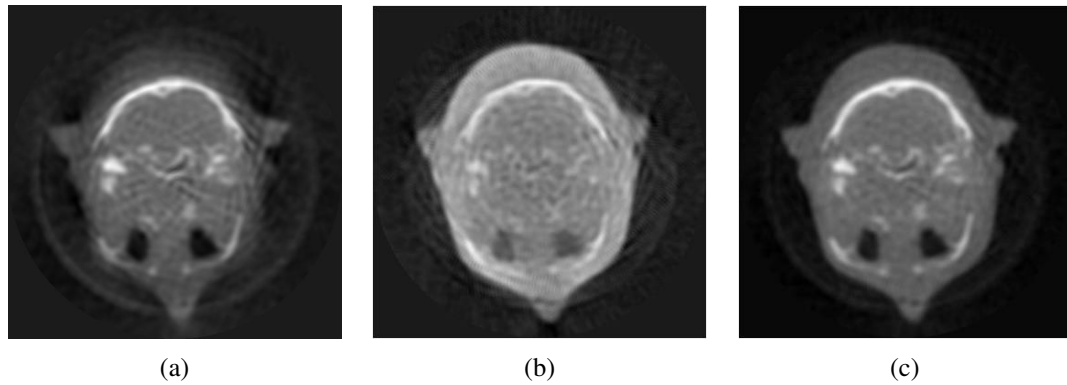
Comparison of the resulting images obtained by combining the fan data created with the old software (a), by adding the images created with the new software for the C-arm device (b) and for the CT scanner (c).
